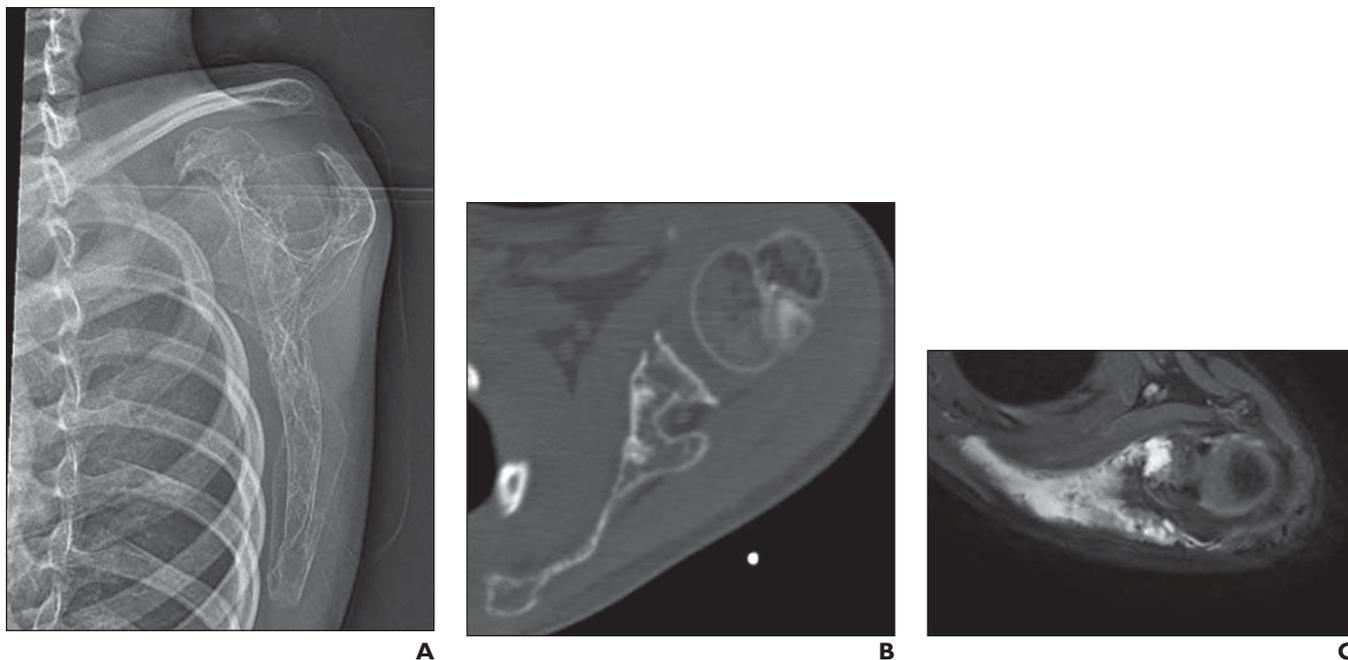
9-year-old girl who initially presented with left shoulder pain from Gorham-Stout disease. A and B, Radiograph (A) and axial CT (B) of left scapula show intramedullary lucent lesions with cortical thinning. C, Axial T2-weighted fat-saturated MRI of scapula shows multiple lobulated foci that are hyperintense throughout scapula, with thinning of cortex.
